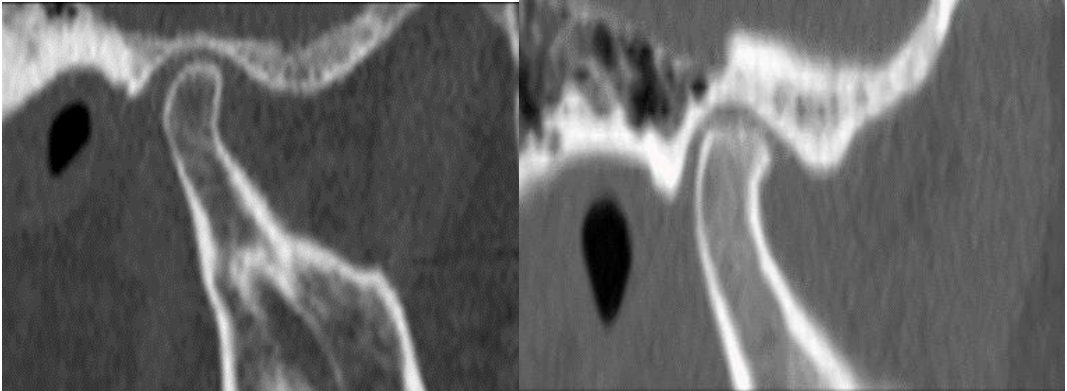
CT showing the TMJ.
